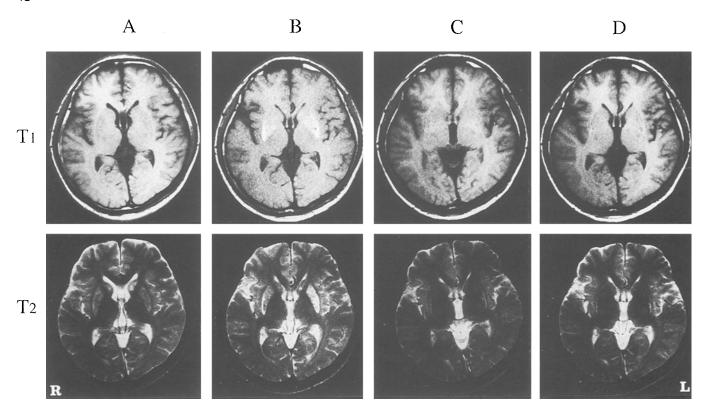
Magnetic resonance (MR) images of the brain. Upper rows; T1-weighted (TR/TE 600/19 ms). Lower rows; T2-weighted (TR/TE 2500/80 ms except B which is 2000/80 ms) images. Upper and lower images in each column were obtained in the same day. A 9th, B 51st, C 146th and D 286th days after poisoning. In T1-weighted images, A largerly normal. B High signal intensity areas were seen in the bilateral putamina. C and D largely normal. In T2-weighted images, A, multiple punctate foci of high signal intensity were seen bilaterally in the putamina and in the heads of caudate nuclei. B Hyperintensity in the putamina became more significant while that of the caudate nuclei decreased. C Abnormal signals in the heads of caudate nuclei disappeared. High signal intensity areas were restricted to the posterio-lateral portion of the putamina. D same as C
